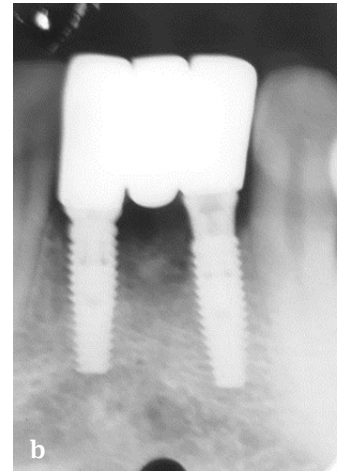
a) Twenty months follow up; b) Intraoral periapical radiograph at 20 months.
